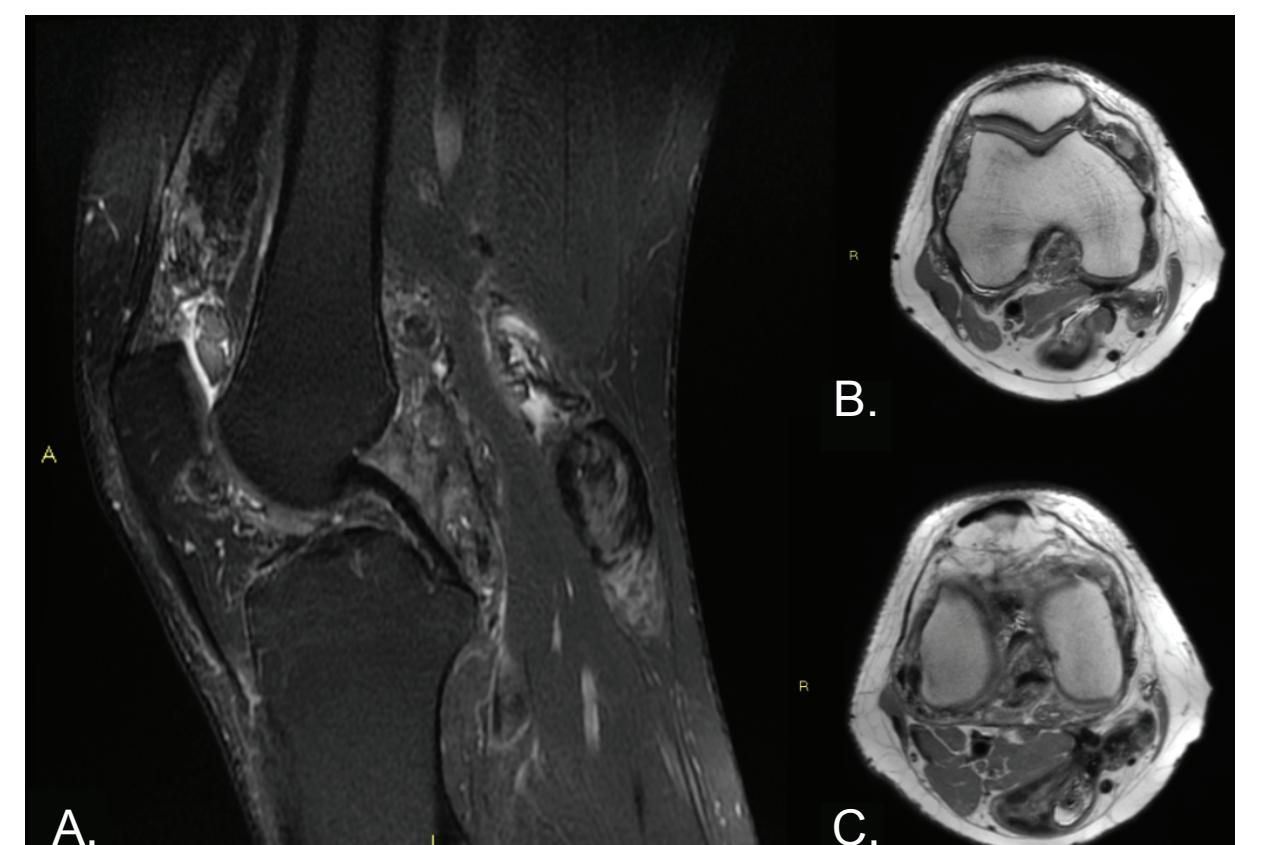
Sagittal (A) and axial (B-C) MRI scans of the patient's knee at the end of treatment with pexidartinib
